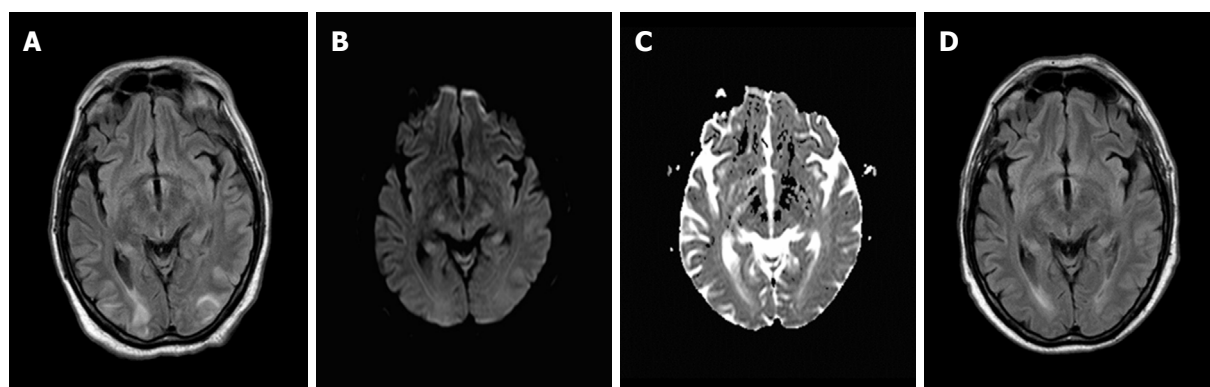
Brain magnetic resonance imaging scans demonstrating: symmetrical high intensity signals in the subcortical white matter of the occipital lobes at onset on FLAIR images (A), whereas a very mild changes on DWI and ADC sequences (B and C), and imaging remission after 10 days on FLAIR images (D)
